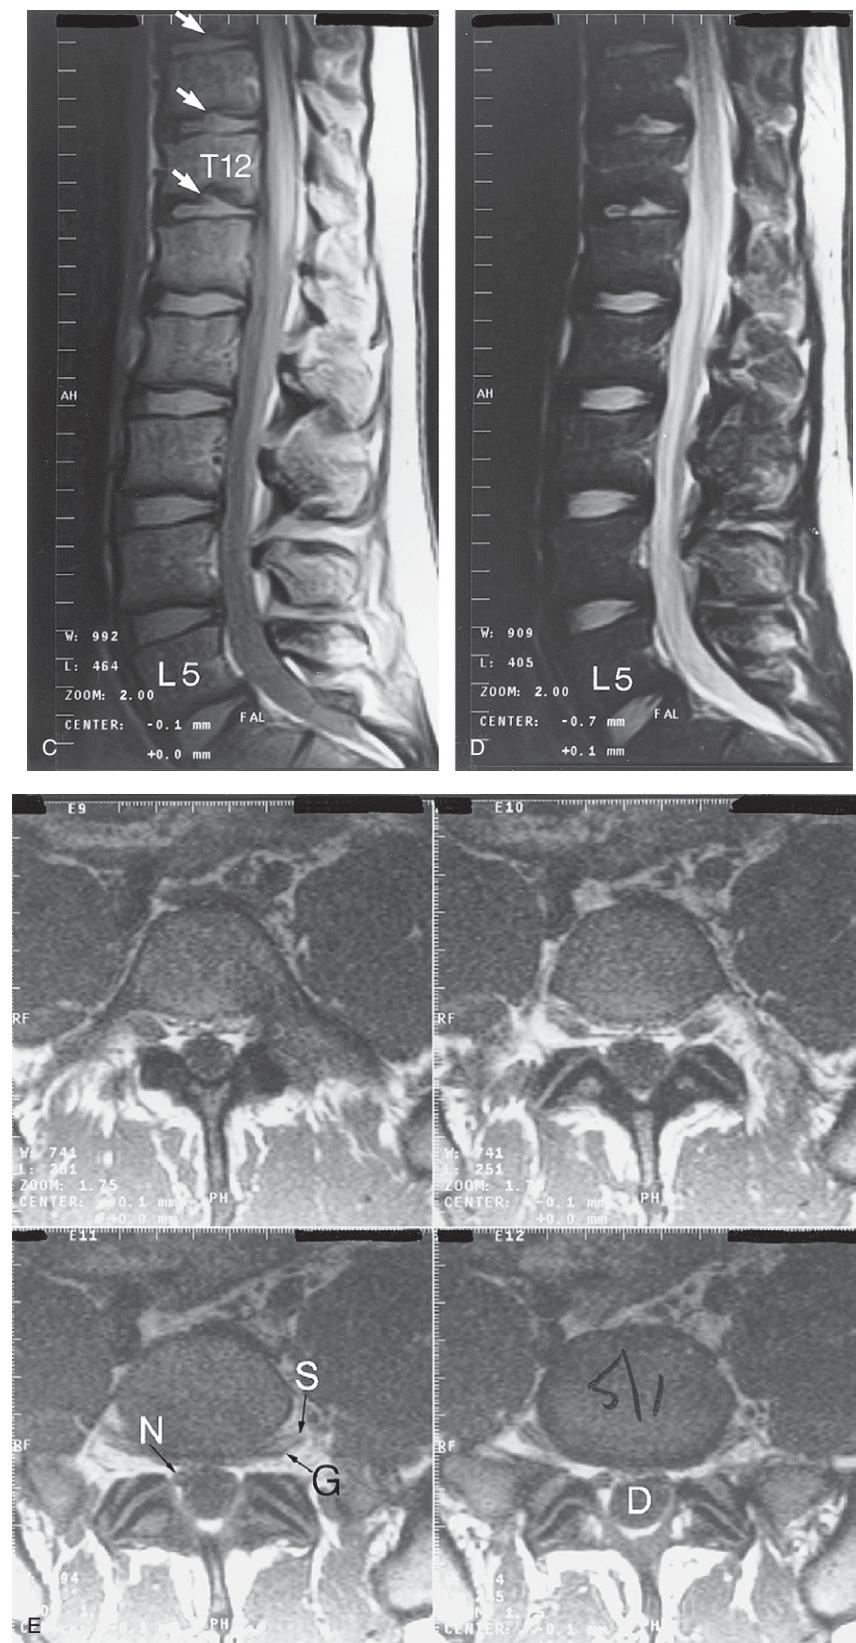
Cont'd (C) Lumbosacral spine MRI sagittal T1-weighted image. Note the Schmorl's nodes (vertebral body end plate fractures due to vertical rupture of nucleus pulposus material) at the T10, T11 and T12 levels (white arrows). (D) Lumbosacral spine MRI sagittal T2-weighted image. (E) Normal MRI axial images of the L5-S1 level. Note the nerve root (N), spinal ganglion (G) and spinal nerve (S). D = Dural tube; RF = right side of patient.
